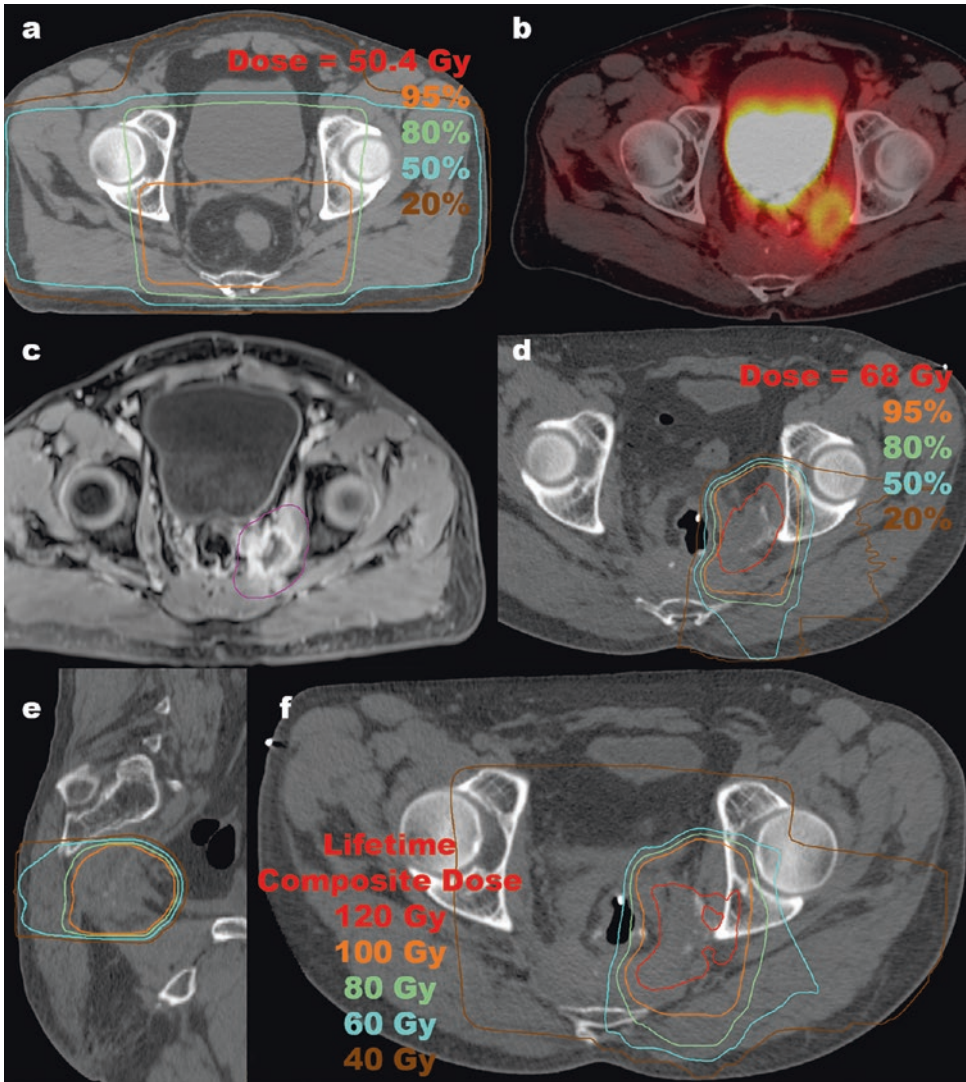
A 63-year-old man was reirradiated for a posterolateral pelvic side wall recurrence of rectal adenocarcinoma. He originally presented with a T2 N2 rectal adenocarcinoma, KRAS wild type, and was treated with preoperative radiation therapy to 50.4 Gy with continuous infusion 5-fluorouracil (a). He then underwent a low anterior resection with a pathologic complete response, with 0/3 lymph nodes being involved. He had poor tolerance of planned adjuvant capecitabine and so received no adjuvant therapy. Four and a half years after surgery, he developed a rising CEA with a PET/CT showing a hypermetabolic (SUV 4.2) mass at the left pelvic sidewall (b), with a CT-guided FNA showing recurrent adenocarcinoma consistent with his rectal primary. He was not felt to be a candidate for radical surgical resection due to tumor location. He was referred for salvage proton therapy, which was initially denied by insurance. He received FOLFOX4 plus bevacizumab for 4 months while awaiting
